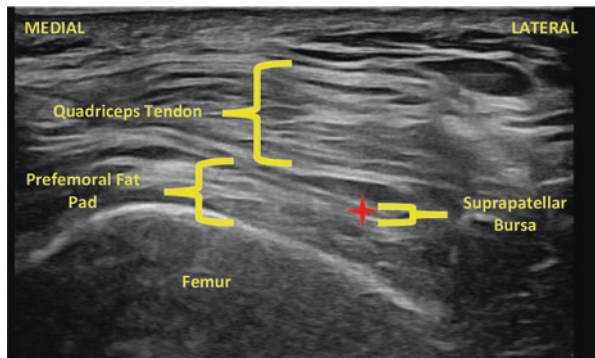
Proximal to distal long axis ultrasound view (anatomy labeled). Red cross indicates needle tip target in suprapatellar bursa
